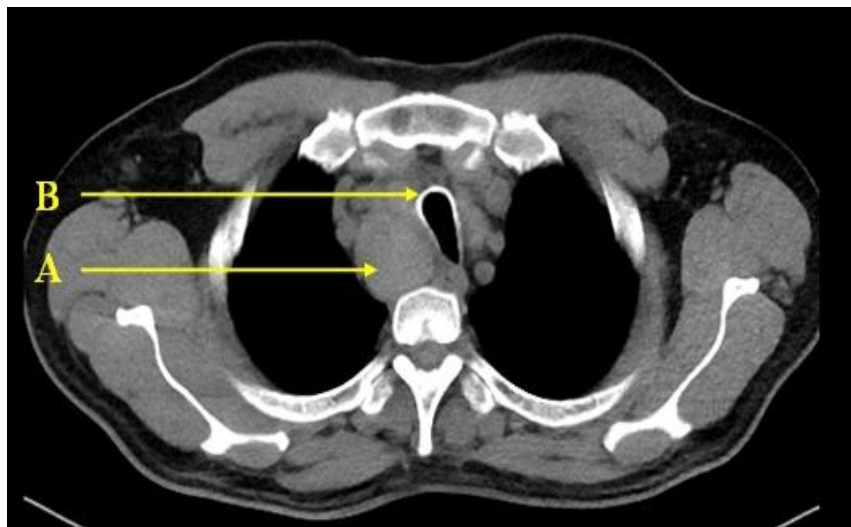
CT - Thorax showing soft tissue mass lesion arising from right lobe of thyroid(A) causing mass effect over trachea with minimal transverse diameter measuring 8.0 mm(B).
